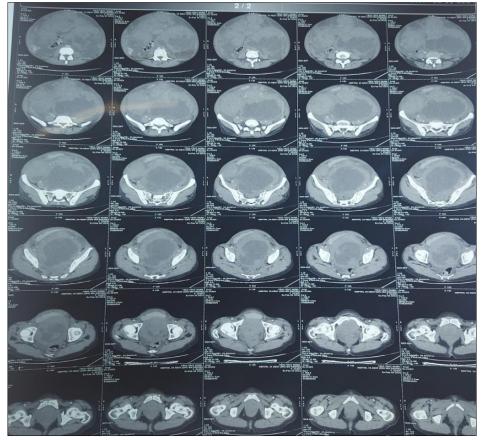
CT abdominal scan showing multiple tumescent masses.
